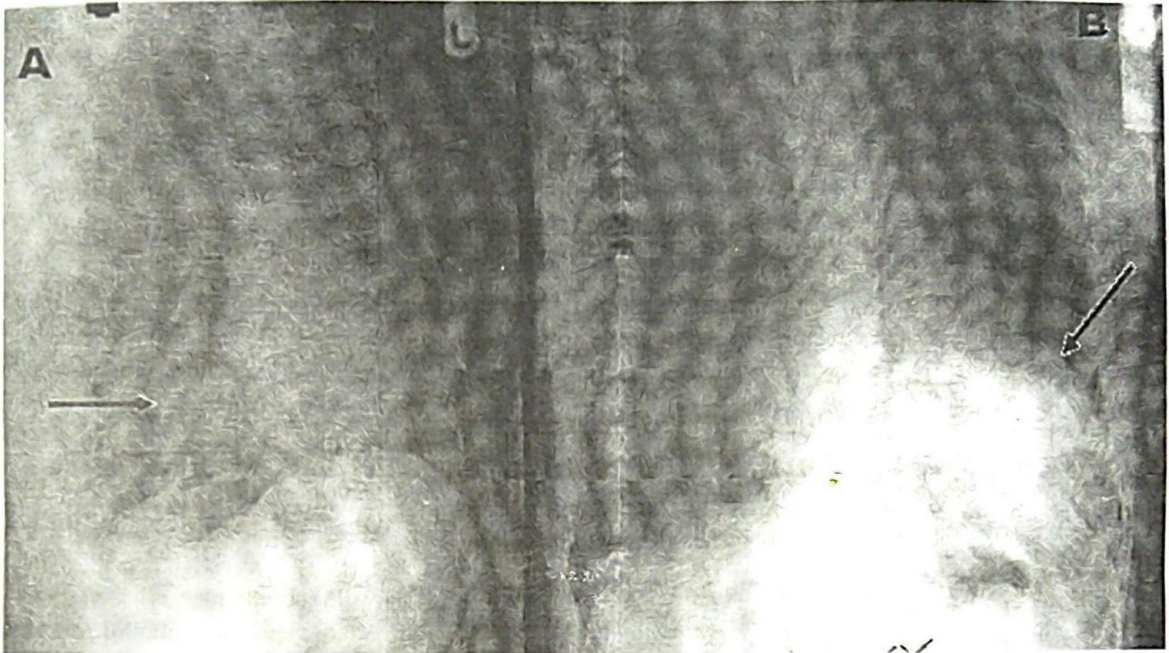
Chest radiograph. A = Left lateral view, B = posterior-anterior view. Arrow points to the cyst.
